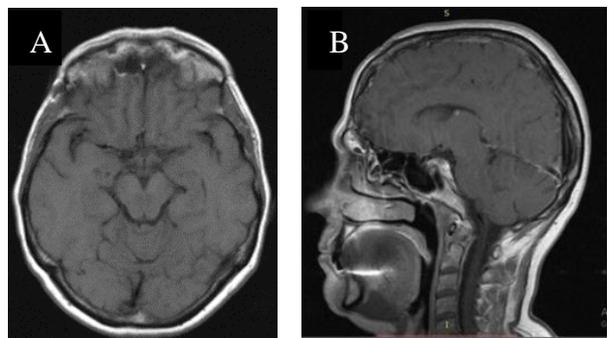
Axial (A), sagittal (B) and coronal (C) contrast MRI images revealing a planum sphenoidale meningioma
